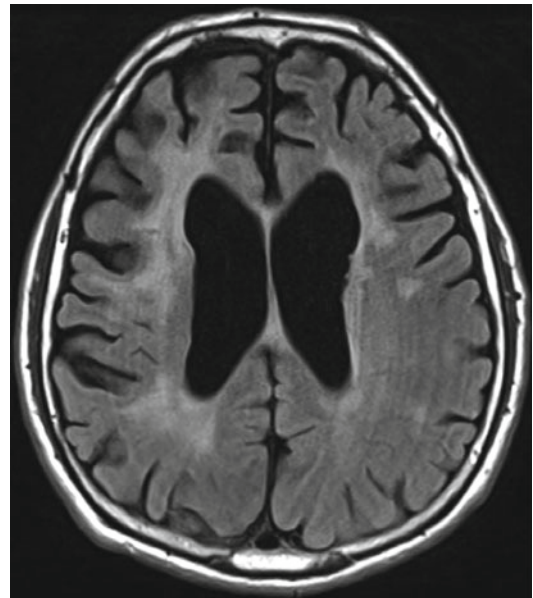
Late neurotoxicity on MRI. T2 sequences show periventricular white-matter changes and brain atrophy
